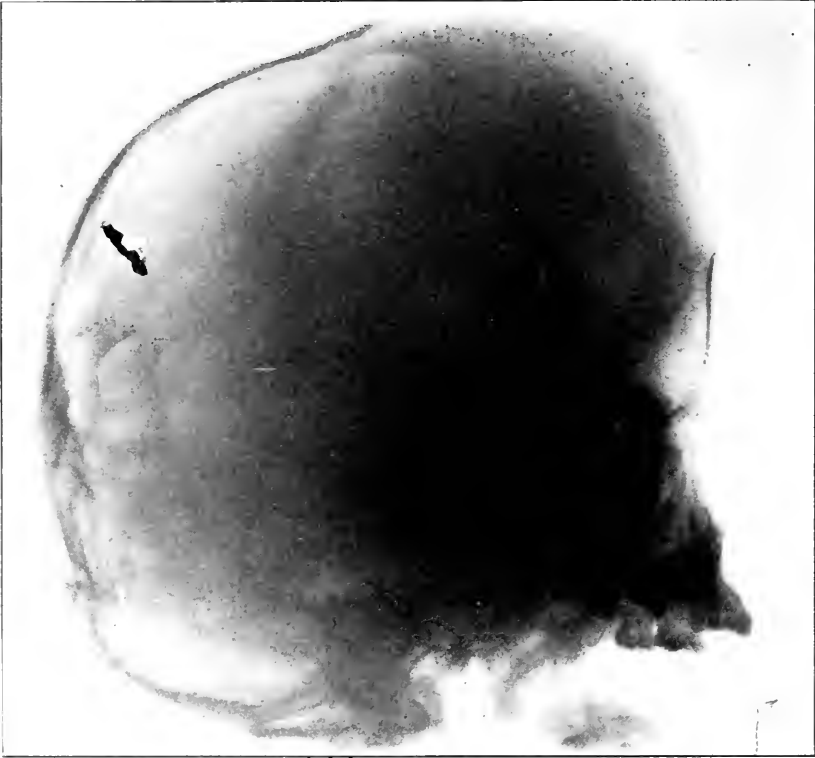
Roentgenogram of skull.
